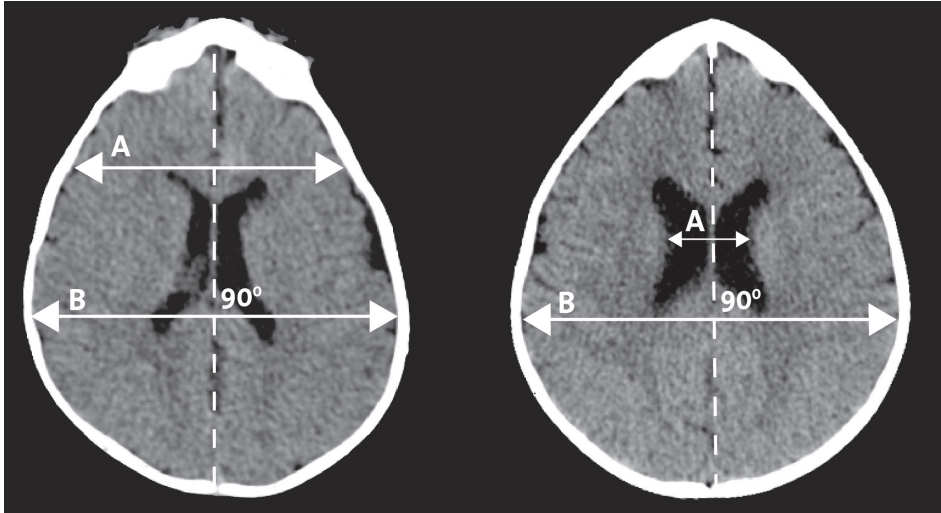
CT-scan showing the severity of frontal stenosis measuring the ratio of the interparietal distance (B) to the intercoronal distance (A) (3, 26).
